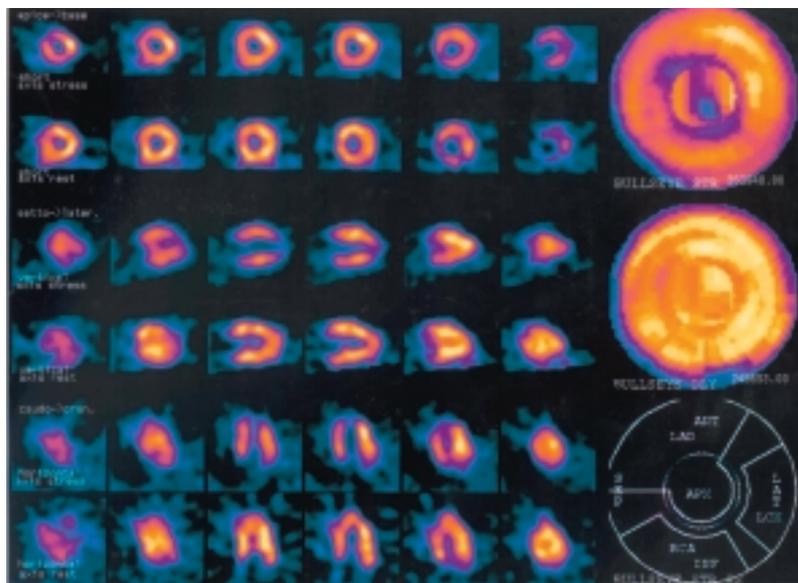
Case 1: thallium-201 myocardial scintigraphy which showed a clear reversible apical perfusion defect.
